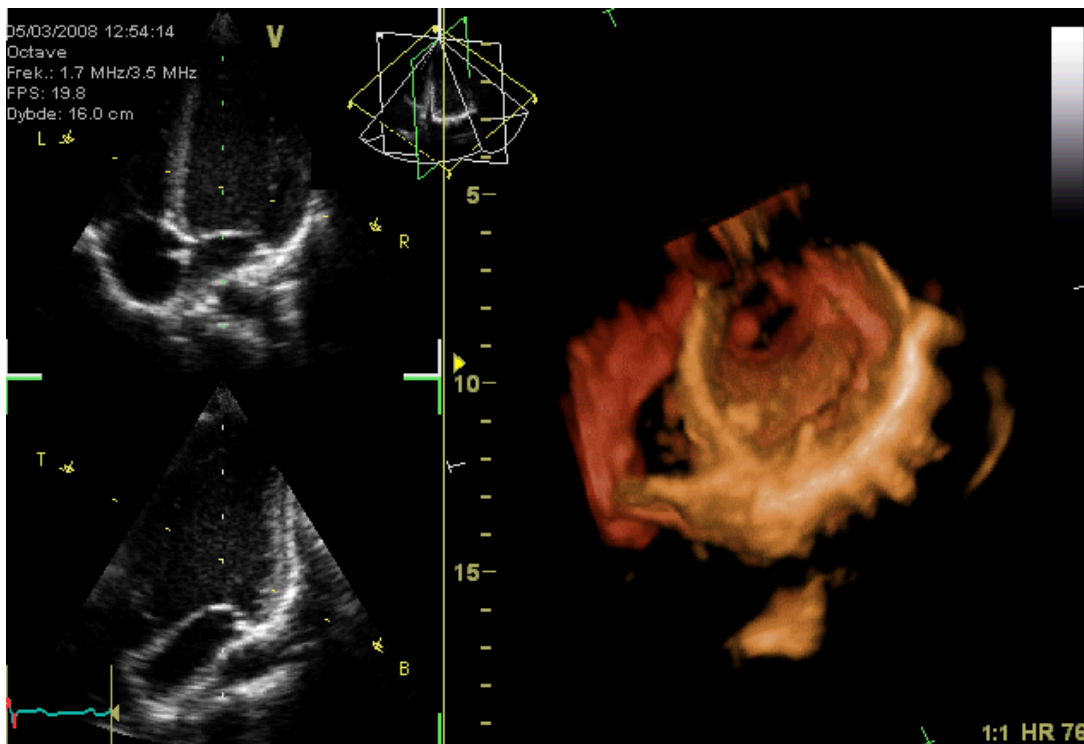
"GIF-animation showing a moving echocardiogram; a 3D-loop of a heart viewed from the apex, with the apical part of the ventricles removed and the mitral valve clearly visible. Due to missing data, the leaflet of the tricuspid and aortic valve is not clearly visible, but the openings are. To the left are two standard two-dimensional views taken from the 3D dataset." by Kjetil Lenes. License: [CC BY-SA 3.0](https://creativecommons.org/licenses/by-sa/3.0/)
